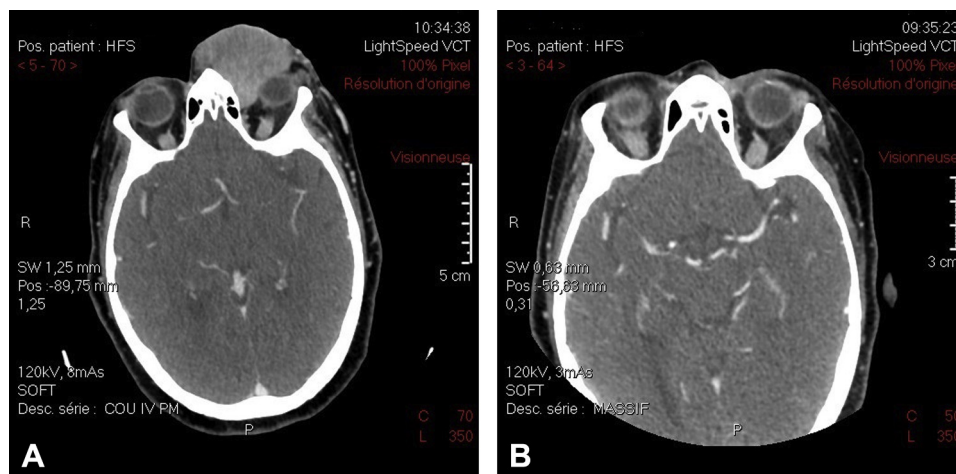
Facial CT scan examination before treatment and after 20 months of imatinib. A, Voluminous mass with intraorbital extension before treatment. B, Complete remission of the tumor after 20 months of imatinib.
